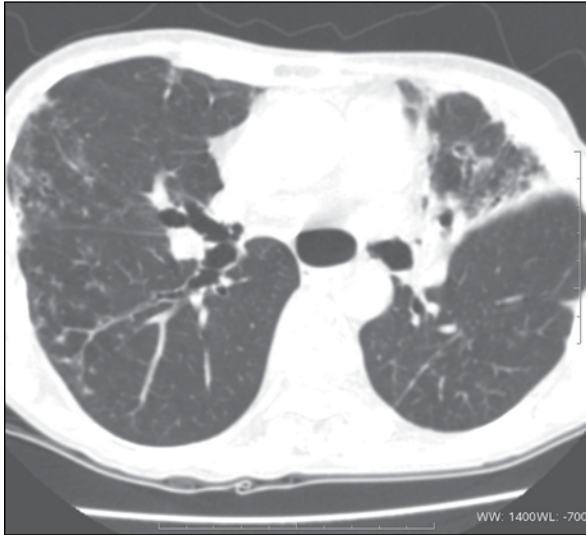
Computed tomography of the thorax reveals bronchiectasis, with centrilobular nodules in a tree-in-bud pattern at the right middle and lower lobes and the lingular segment, suggesting active endobronchial sepsis
